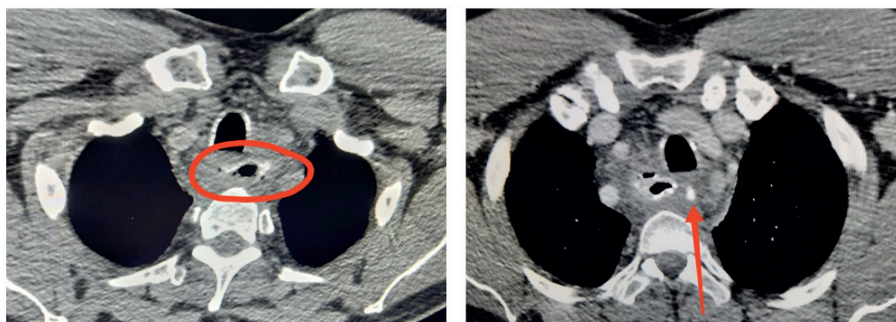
CT with IV and oral contrast. A: Esophageal foreign body. B: Extravasation of oral contrast suggesting esophageal perforation.
